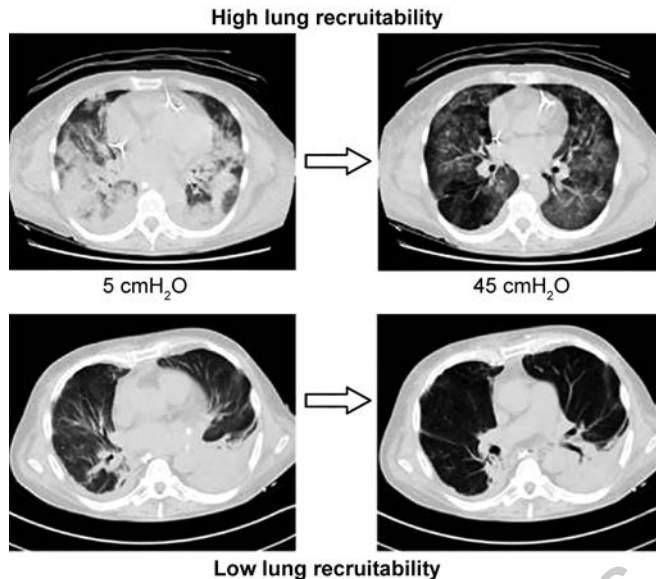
Example of lung CT scan of patients with high or low potential of lung recruitment. Arrows depict the morphologic change from a condition of low airway pressure (i.e. 5 cmH₂O), to one of high airway pressure (i.e. 45 cmH₂O). Higher PEEP should be considered in the case of high recruitability. (modified with permission from: Umbrello M. et al. *Int J Mol Sci* 2017).
